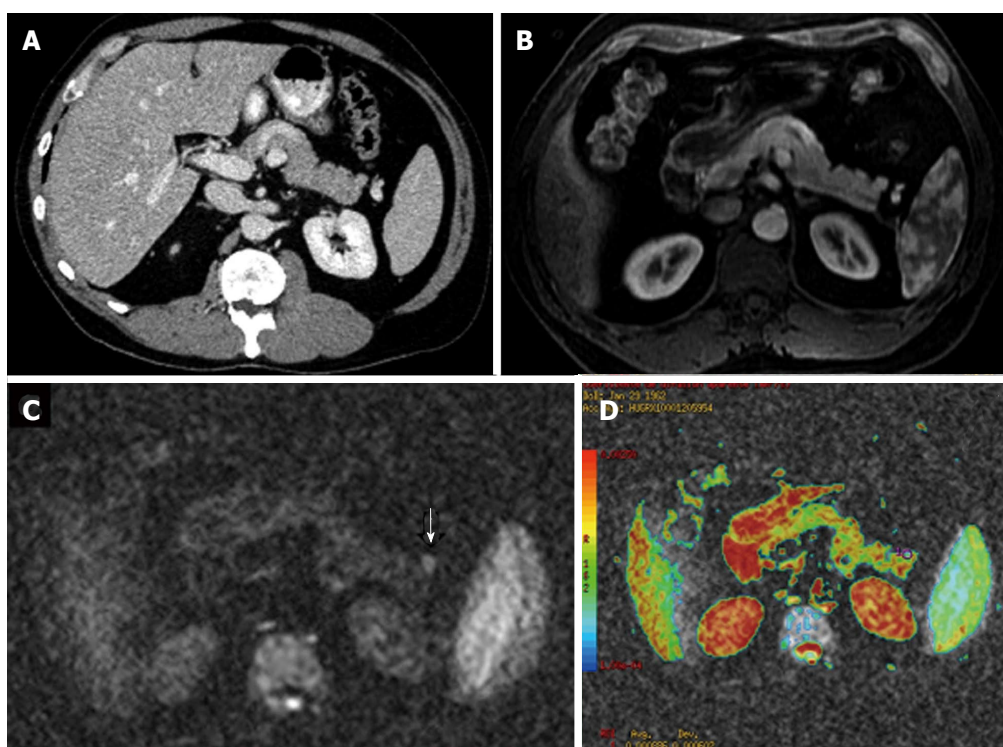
Use of diffusion-weighted magnetic resonance imaging in the earlier detection of pancreatic tumours. Axial contrast enhanced multidetector computed tomography image (A) and axial arterial-phase gadolinium-enhanced T1-weighted fat-suppressed gradient-recalled echo magnetic resonance image (B) do not depict any abnormality. Axial diffusion-weighted magnetic resonance imaging (C) demonstrates a focal increased signal intensity (arrow) and low apparent diffusion coefficient values in the color coded images (D).
